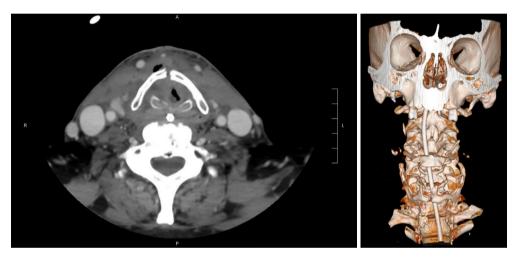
(D2900552 CT neck soft tissue from 1/11/2021). Displaced fracture of the thyroid cartilage and cricoid, with associated air within the soft tissues. This patient also had numerous other comminuted and displaced fractures of the trachea, including displaced fractures of the hyoid bone and arytenoid cartilage. The tracheal rings were not discretely visualized, and the airway appeared effaced. Pneumomediastinum was also noted. CT, computed tomography.
